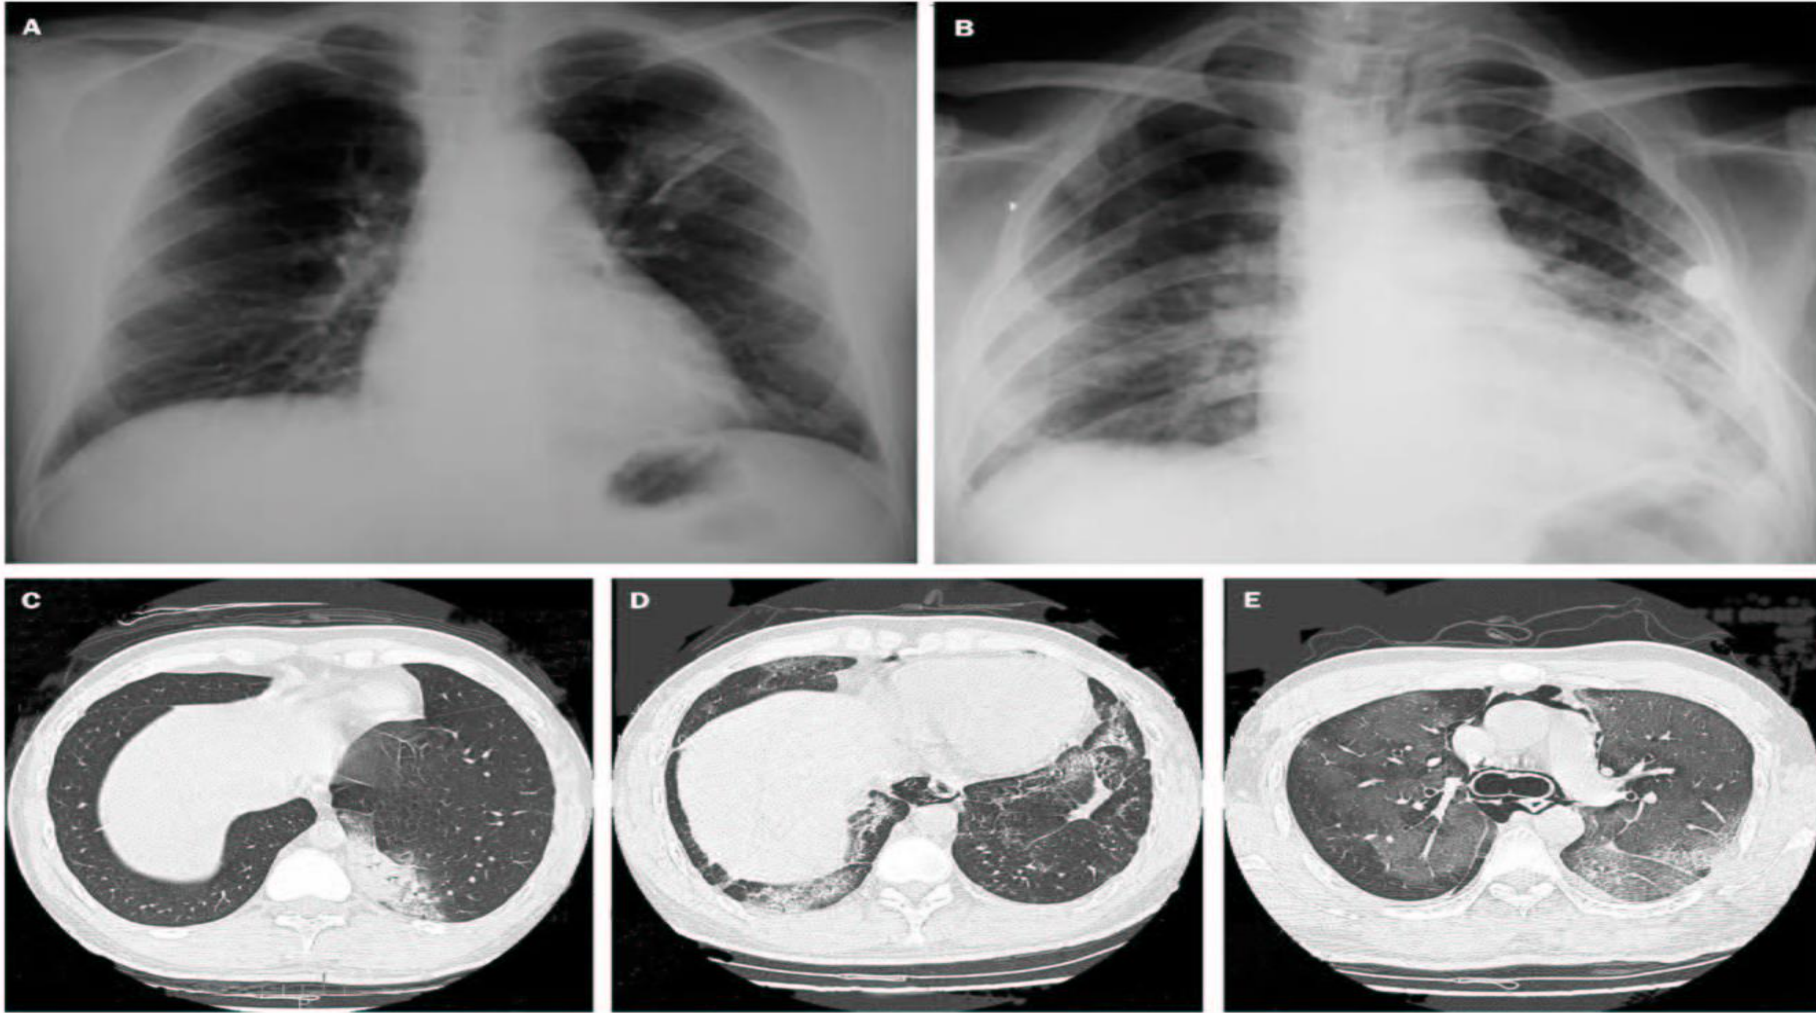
Chest radiographs and high-resolution CT scans from two SARS patients
